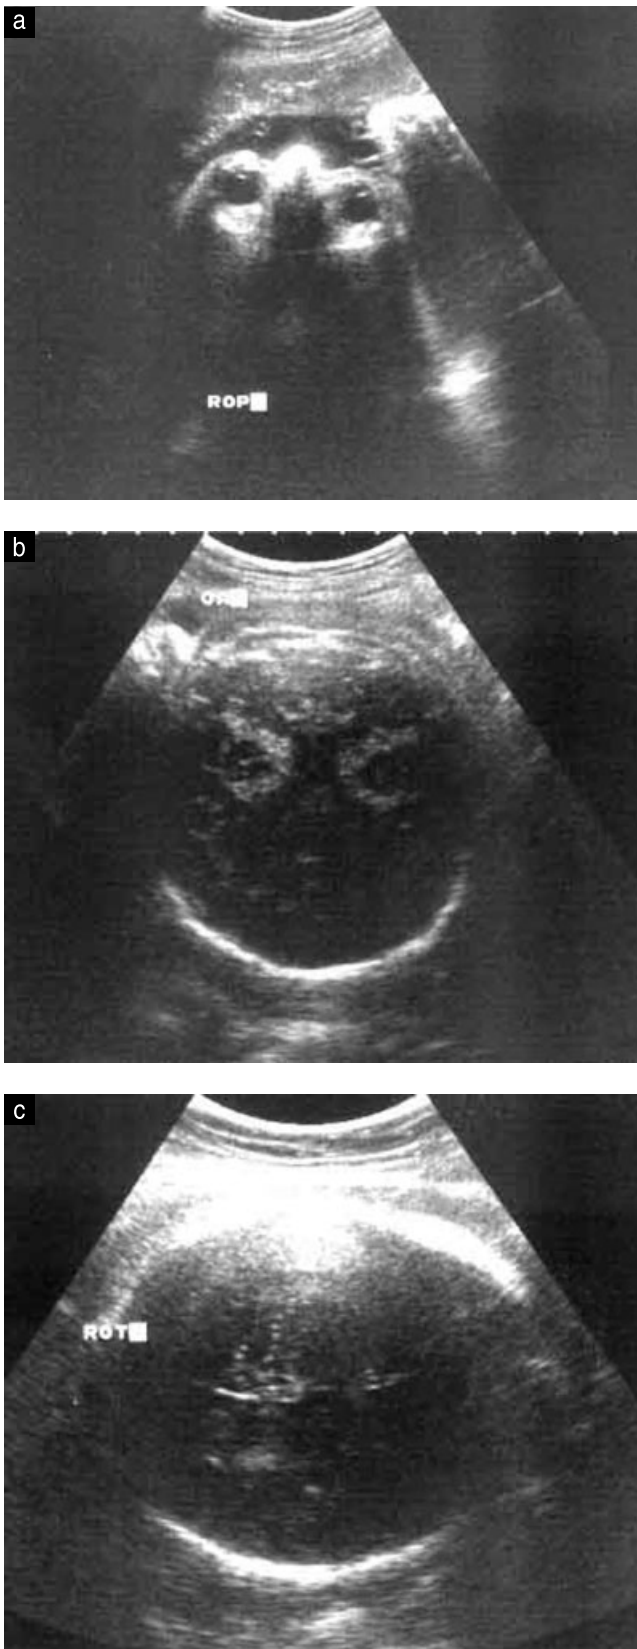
Occipital positions on ultrasound. (a) Occiput posterior. (b) Occiput anterior. (c) Occiput transverse.
